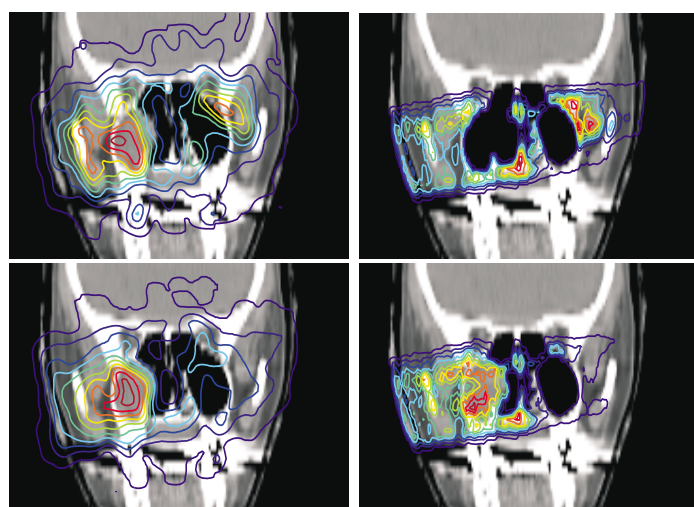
Left: Higher activation at the distal edge of the portal (entering the patient from the left of the picture) in the PET measurement (up) in comparison with the prediction (down). Right: The recalculation with (up) and without (down) CT modification well resembles the PET images (left), thus supporting the hypothesis.
